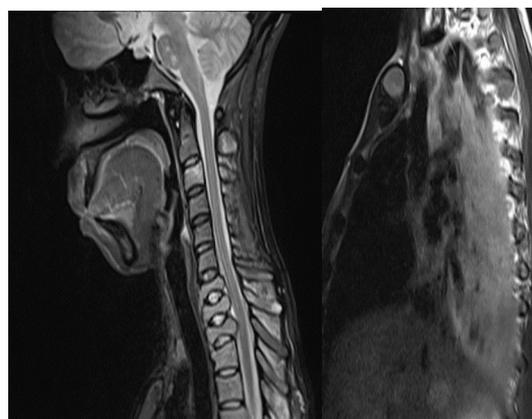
MRI whole spine, sagittal view; Fracture of the seventh cervical to second thoracic vertebra and compression of the spinal cord
